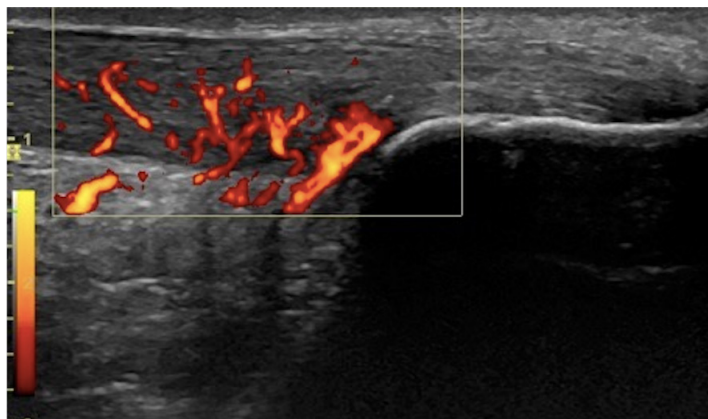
Achilles tendinopathy studied with high-definition color Doppler ultrasound. Longitudinal view reveals intensive hypervascularization (*) combined with hypoechoic zones. Important tendon thickening was detected.
